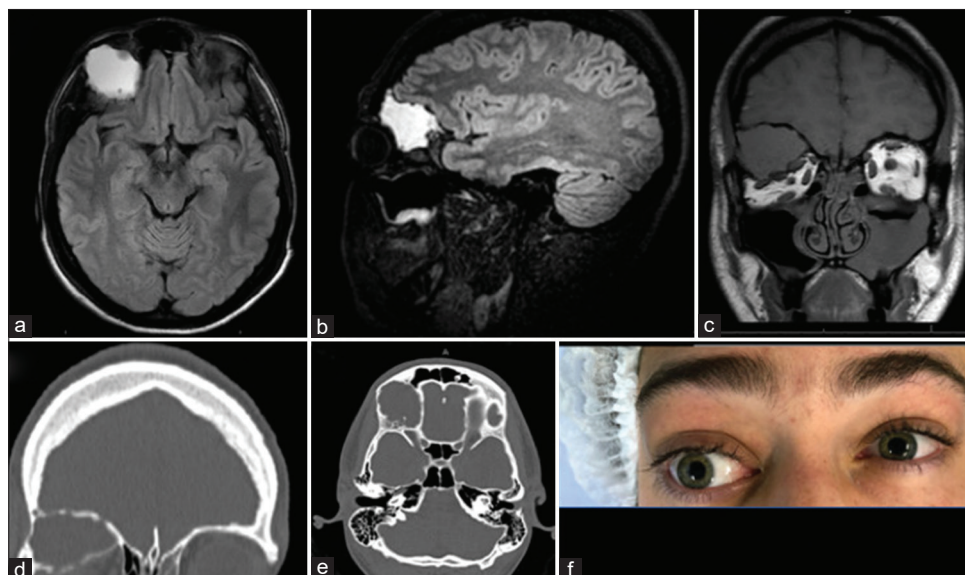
Expansive cystic bone formation in the right orbital roof, with peripheral enhancement through contrast with thin septations, measuring $3.3 \times 4.0 \times 2.8$ cm (LL \times AP \times CC). It presents clear limits, with a “frosted glass” aspect in the bone portion in its periphery, especially in its inferomedial aspect. (a-c) Magnetic resonance imaging images, axial, sagittal, and coronal view, respectively. (d and e) Computed tomography images, coronal and axial view (f) there is consequent degree I proptosis of this side and displacement of the optic nerve.
